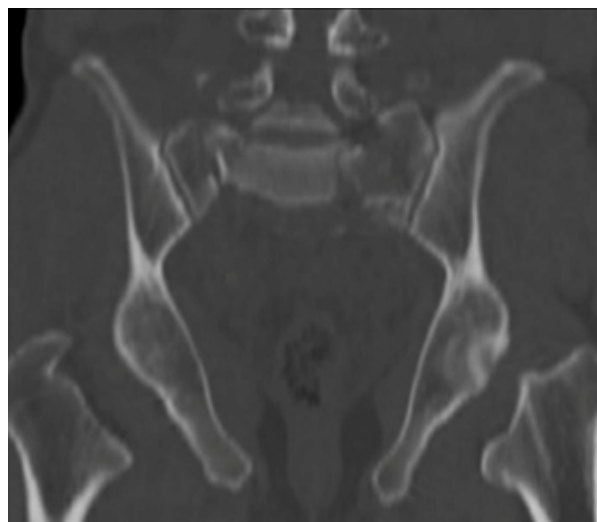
Axial CT cut showing fractures of the bilateral sacral ala
